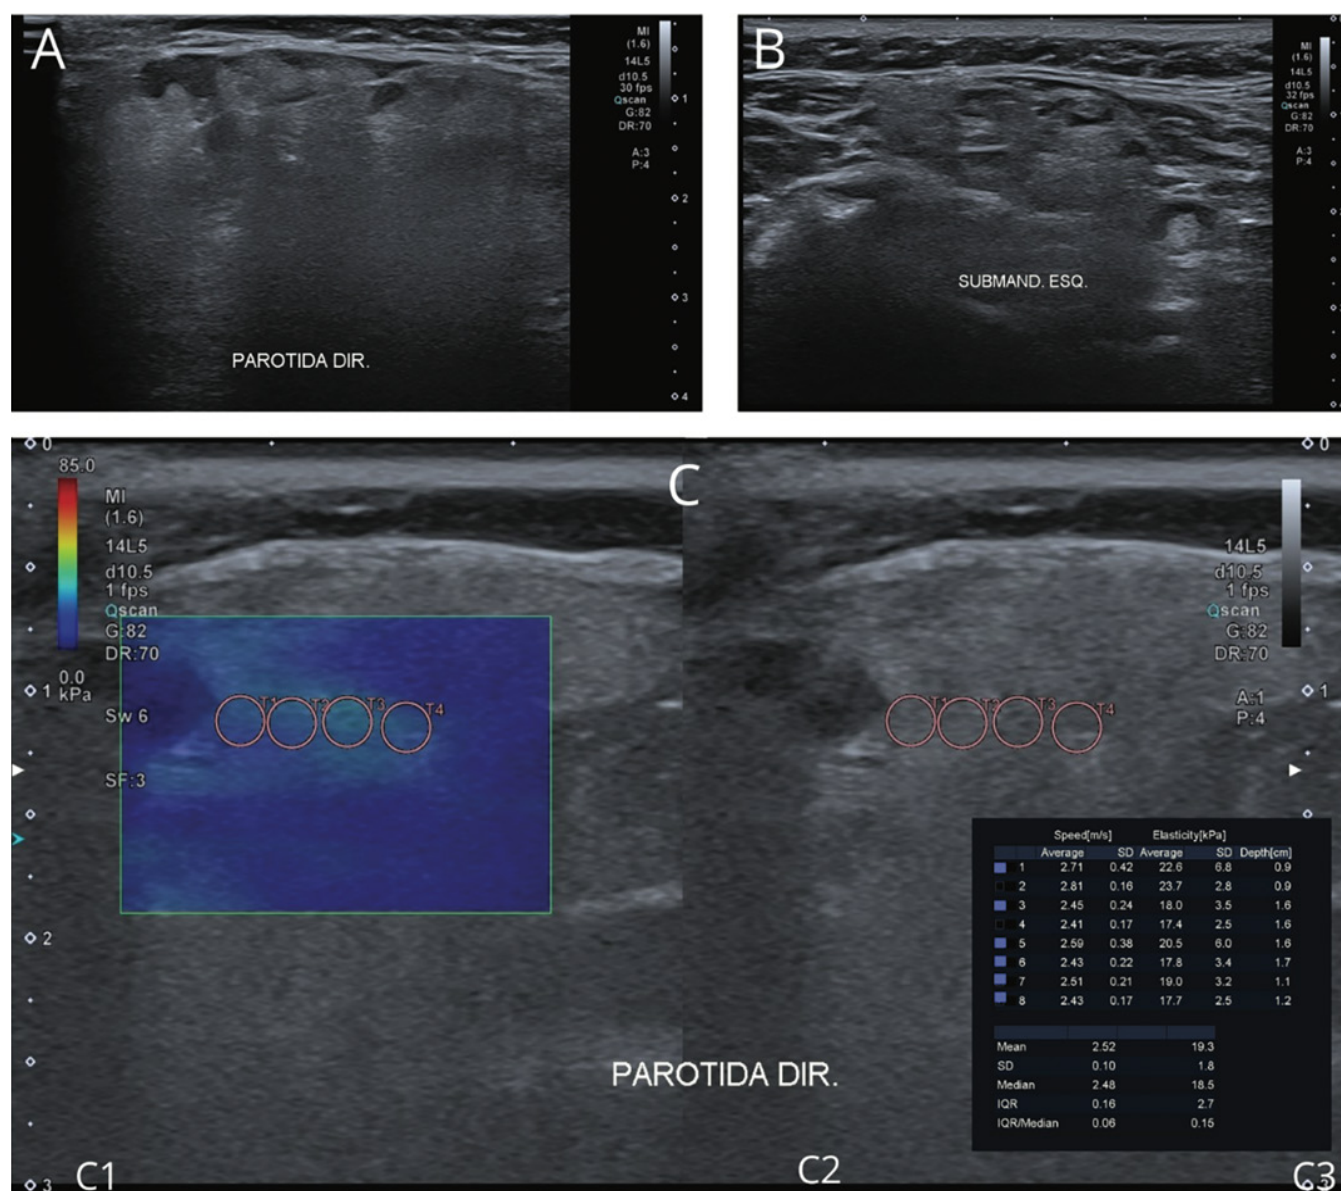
B-mode ultrasound and 2D-shear wave elastography of the major salivary glands in a patient with Sjögren Disease. A) B-mode ultrasound grade 2 in the right parotid gland; B) B-mode ultrasound grade 3 in the left submandibular gland; C) 2D-shear wave elastography parameters in the right parotid gland [elasticity (kPa) and shear wave velocity (m/s)]; C1) color-coded image with placement of the Q-box and four quantification cursors; C2) corresponding B-mode ultrasound image of the right parotid gland; C3) obtained values of the eight consecutive quantification cursors and the mean of the elasticity and the shear wave velocity of the six selected measurements.
